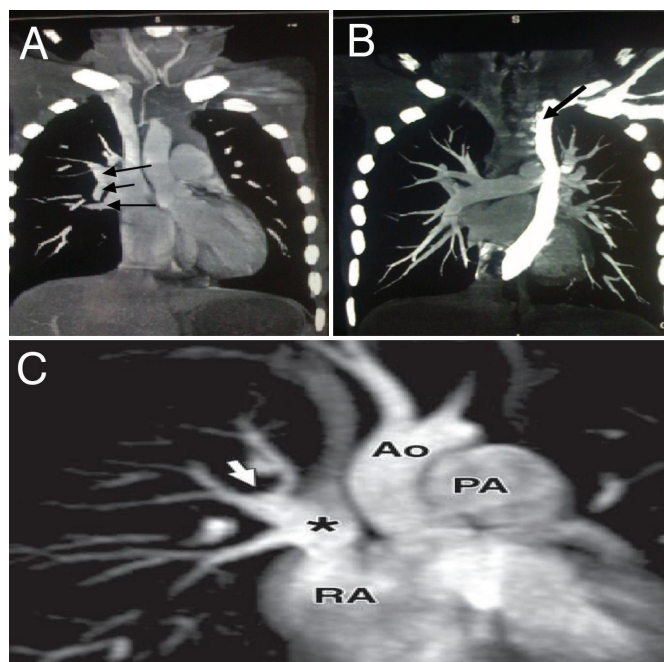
Preoperative cardiac multidetector computed tomography. A, Three pulmonary veins opening into the right atrium (RA) near the superior vena cava (SVC) (black arrows). B, Left persistent SVC opening into the coronary sinus (black arrow); notice the absence of the innominate vein. C, Third chamber formed by 3 pulmonary veins (*) opening into the SVC-RA junction. Ao indicates aorta; PA, pulmonary artery; RA, right atrium.
